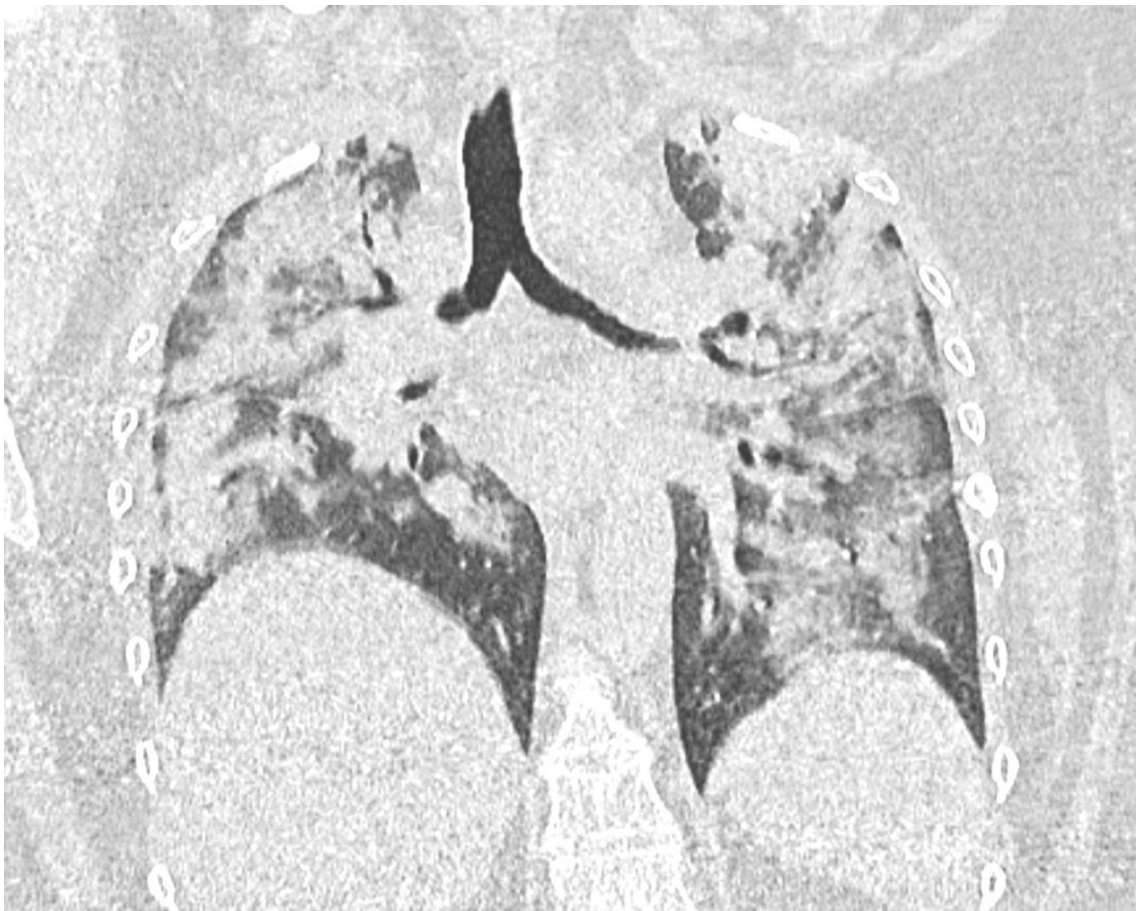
Reconstructed chest X-ray (r-CXR) (A) and coronal multiplanar reconstruction MPR of high-resolution computed tomography (HRCT) (B) of a 41 years old female patient with severe COVID-19 pneumonia. Bilateral, diffuse ground glass opacities and consolidations occupy most of the lung parenchyma, and the disease extent was scored as category 2 (>50%) both on r-CXR and HRCT.
